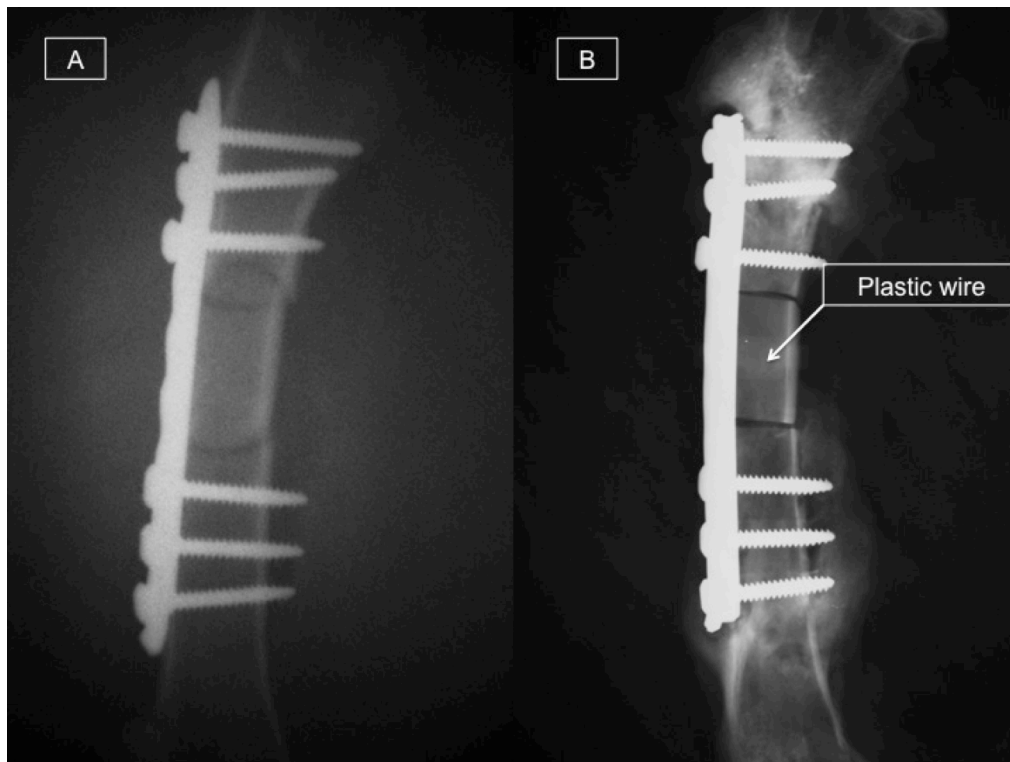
Xray of the femoral allograft fixed with 8 holes DCP plate, screws and plastic cable wires. A) Post operative check, with satisfactory position of the allograft and apparent satisfactory fixation. Note the 3 screws (6 cortices) fixation both proximal and distal in the host bone. B) 6 week post-operative Xray (femur harvested at the end of the experimental time), good fixation maintained at the proximal and distal osteotomies. Note in transparency the shape of the plastic cable. Note the big amount of callus around the screws and the lack of healing at the osteotomy sites.
